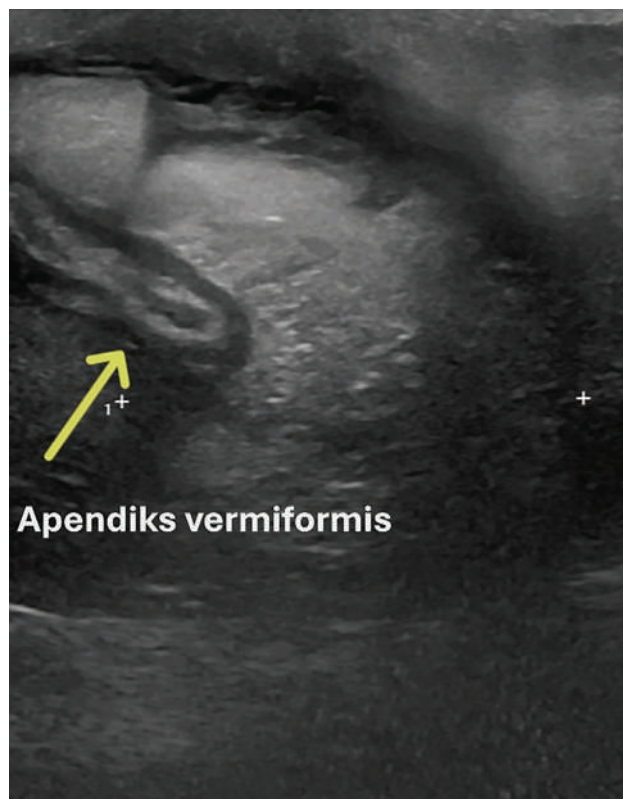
Appendix and bowel loop inside the hernia sac-ultrasonography. The image shows the intestinal loop and appendix within the hernia sac as viewed via ultrasound.
